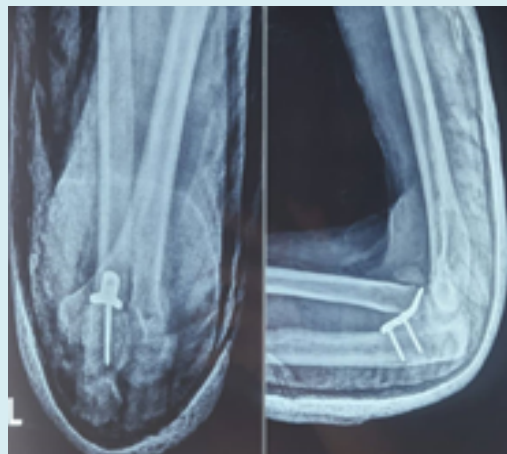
Post-operative radiograph after reduction and fixation.
